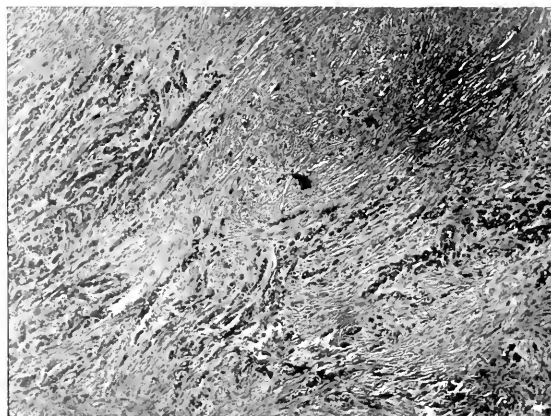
X60: BREAST REMOVED 16 DAYS AFTER COMPLETING X-RAY CYCLE.
